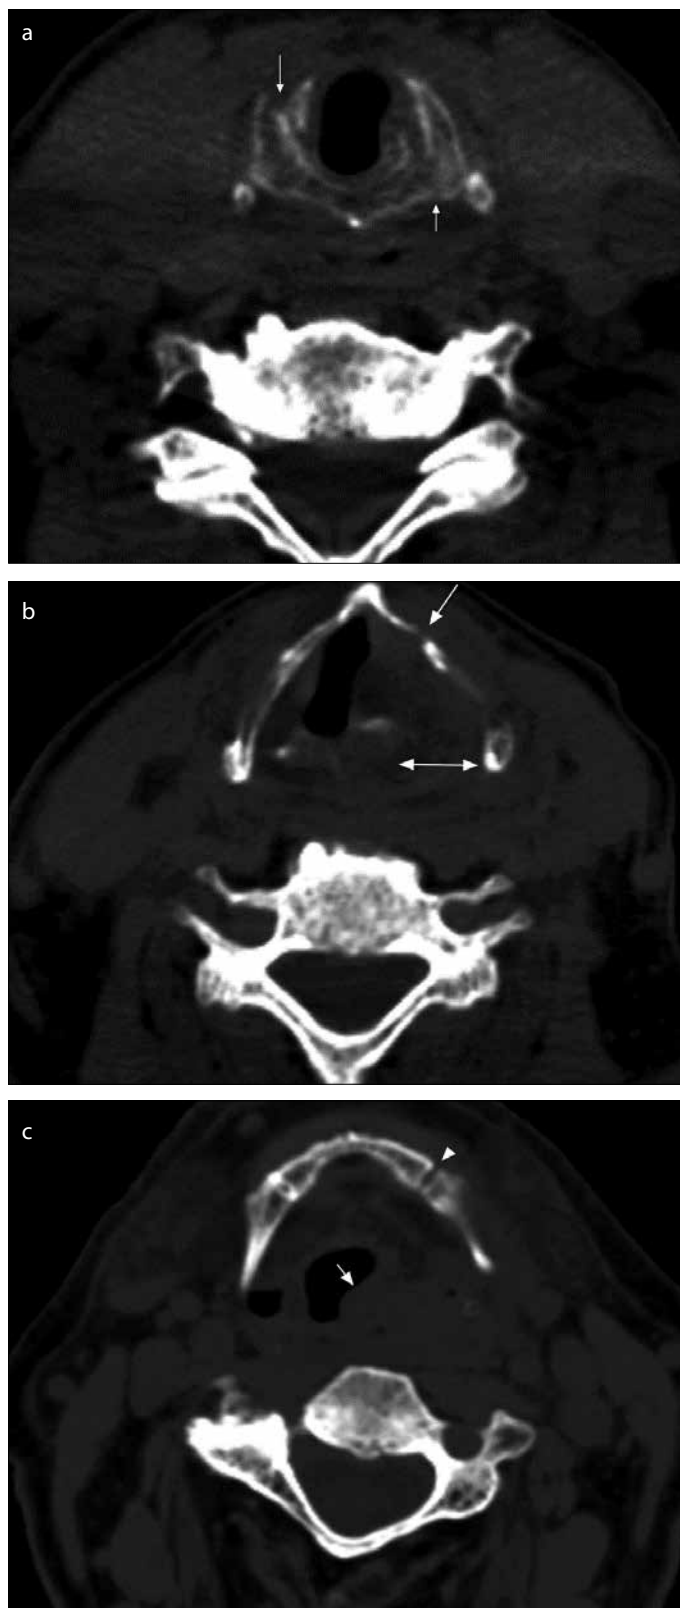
Axial non contrast CT examination shows; (a) multiple minimally displaced cricoid cartilage fracture (arrows), (b) a nondisplaced linear thyroid cartilage fracture (arrow) and cricothyroid joint dislocation (double ended arrow), (c) left aryepiglottic fold and left lateral and posterior pharyngeal wall hematoma (arrow), unilateral absence of bony fusion of the hyoid bone, that was initially suspected as hyoid bone fracture and was diagnosed as synchondrosis of the hyoid bone (arrowhead)
